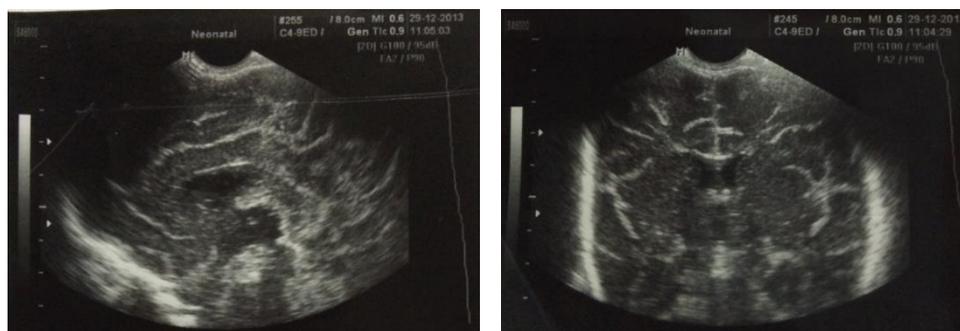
Transfontanelar ultrasound
